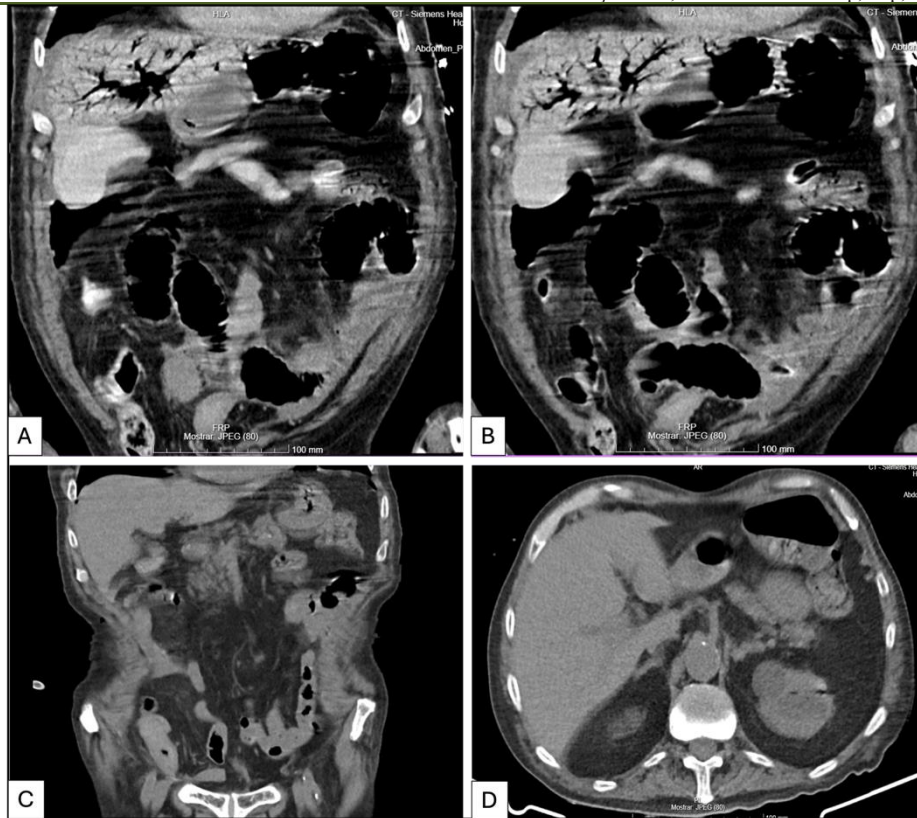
Abdominal CT images of the patient. Upper panels (A, B) show hepatic portal venous gas and intestinal pneumatosis on initial imaging. Lower panels (C, D) demonstrate complete resolution on follow-up imaging during hospitalization
